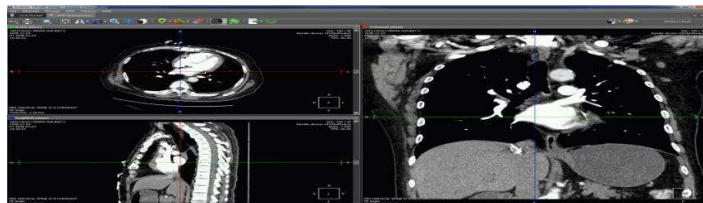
Cardiac CT Multiplanar Reconstruction.
